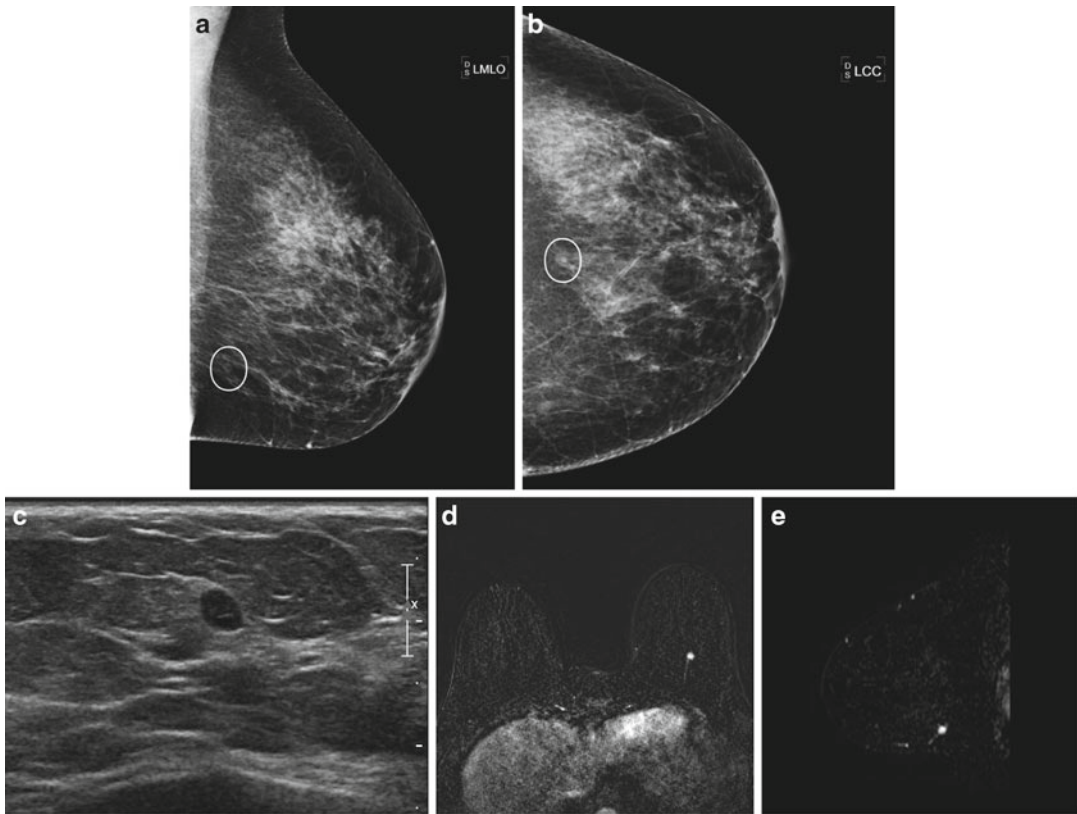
(a, b) Annual left mammogram for a 42-year-old woman with a history of a right mastectomy 3 years prior for infiltrating ductal carcinoma grade 3. She has a family history of breast cancer in her sister and grandmother, both premenopausal at diagnosis. MLO and CC views demonstrate a new circumscribed mass in the lower central left breast. (c) Targeted left breast ultrasound with a 17.5 MHz transducer demonstrates an oval, circumscribed, and hypoechoic mass which is oriented parallel to the skin surface. The mass is located at the 6 o'clock position, 5 cm from the nipple and measured
